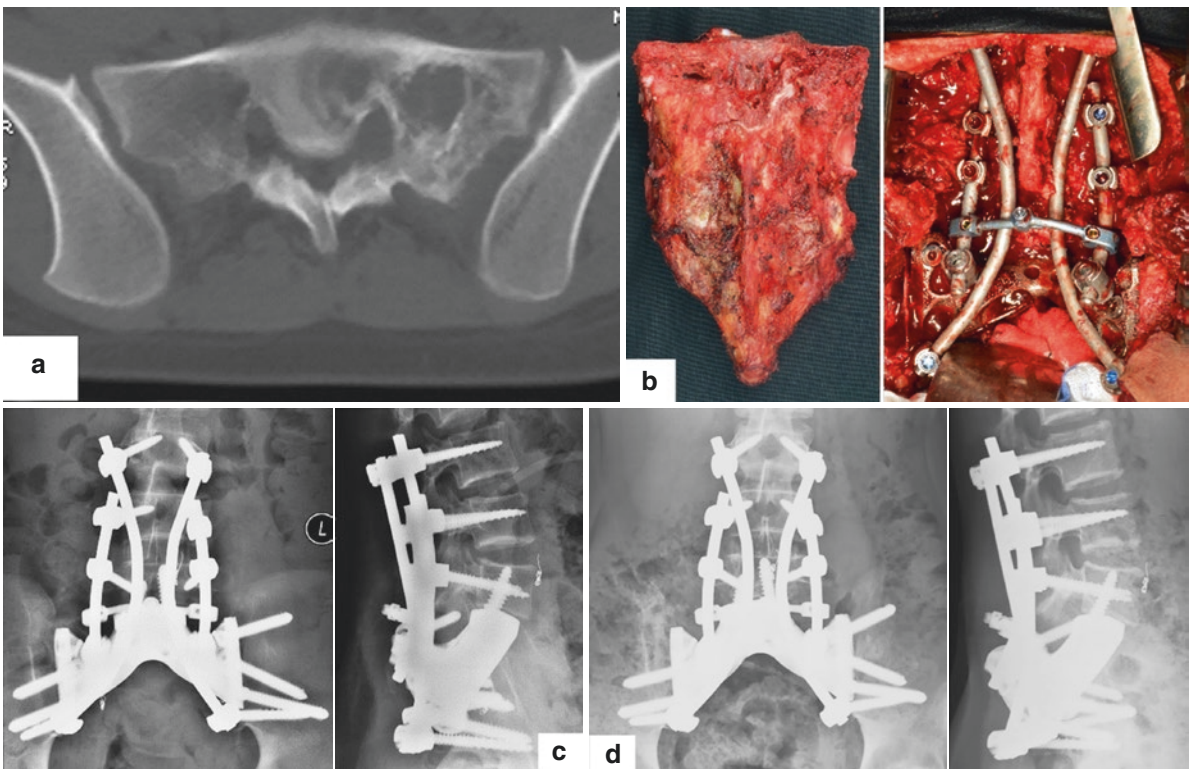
Female, 14 years, sacral Ewing's sarcoma/PNET. (a) Preoperative CT. (b) Tumor-bearing sacrum was en bloc resected and endoprosthesis was settled. (c) X-ray 3 weeks after surgery. (d) X-ray 12 months after surgery. (e) CT scan 12 months after surgery showed new bone formation (arrow). (f) She could walk without aids at last follow-up
